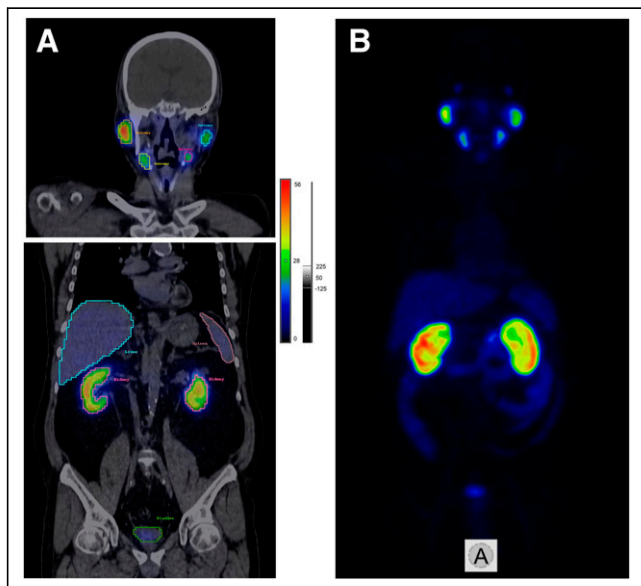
(A) Example of organ delineation in healthy/PCa patient (patient 003) on SPECT/CT images. (B) ^{99m}Tc -PSMA I&S SPECT 3-dimensional maximum-intensity projection.
